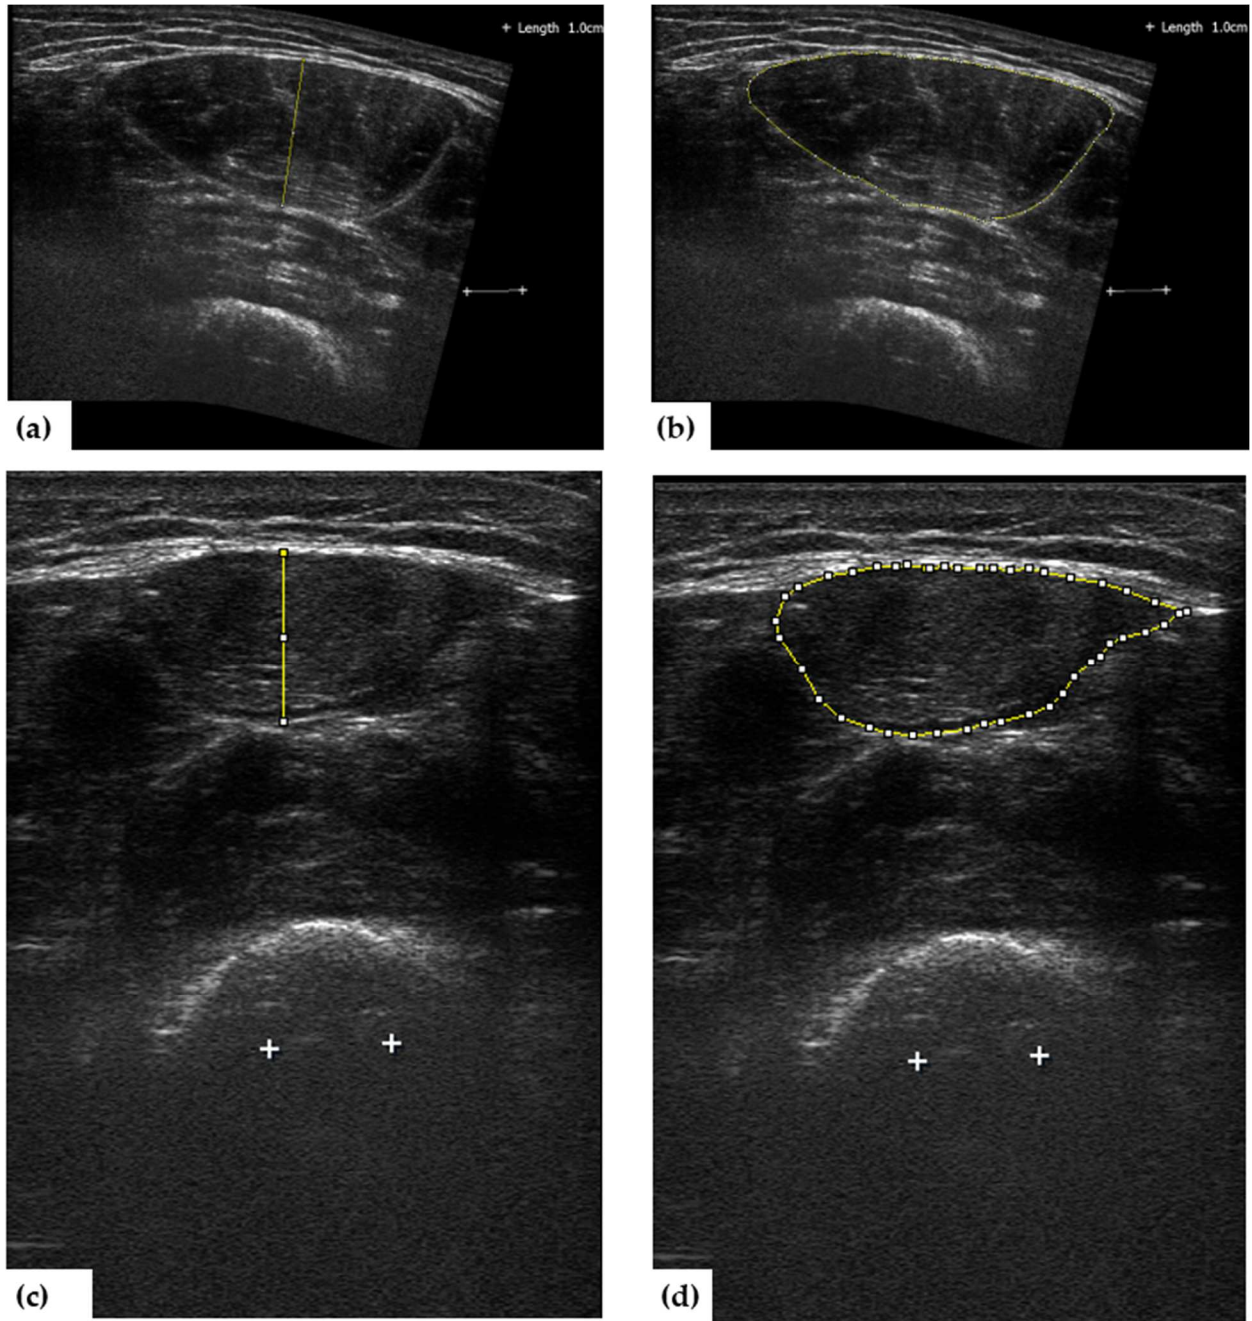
Examples of *rectus femoris* muscle thickness and CSA captured via ultrasonography for one participant. (a) *Rectus femoris* muscle thickness at 50% of leg length captured using the panoramic feature. (b) Same as A but showing muscle CSA. (c) *Rectus femoris* muscle thickness at 75% of leg length captured using a standardized B-mode image. (d) Same as C but showing muscle CSA.
